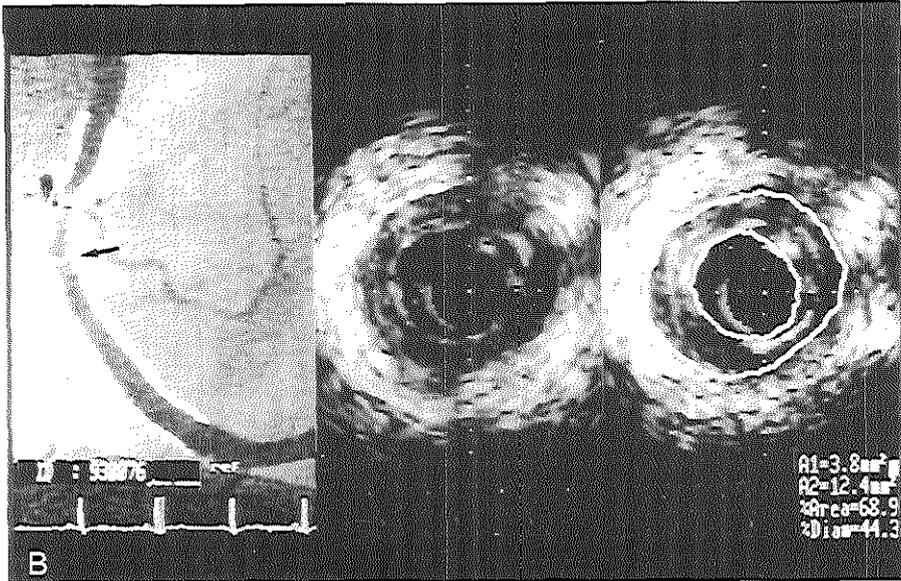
B) Digital angiogram of a right coronary artery with the reference diameter positioned at the site examined with intracoronary ultrasound. Note that in this angiographically normal reference segment intracoronary ultrasound shows the presence of a concentric plaque inducing a 44% diameter stenosis. Calibration: 0.5 mm.
